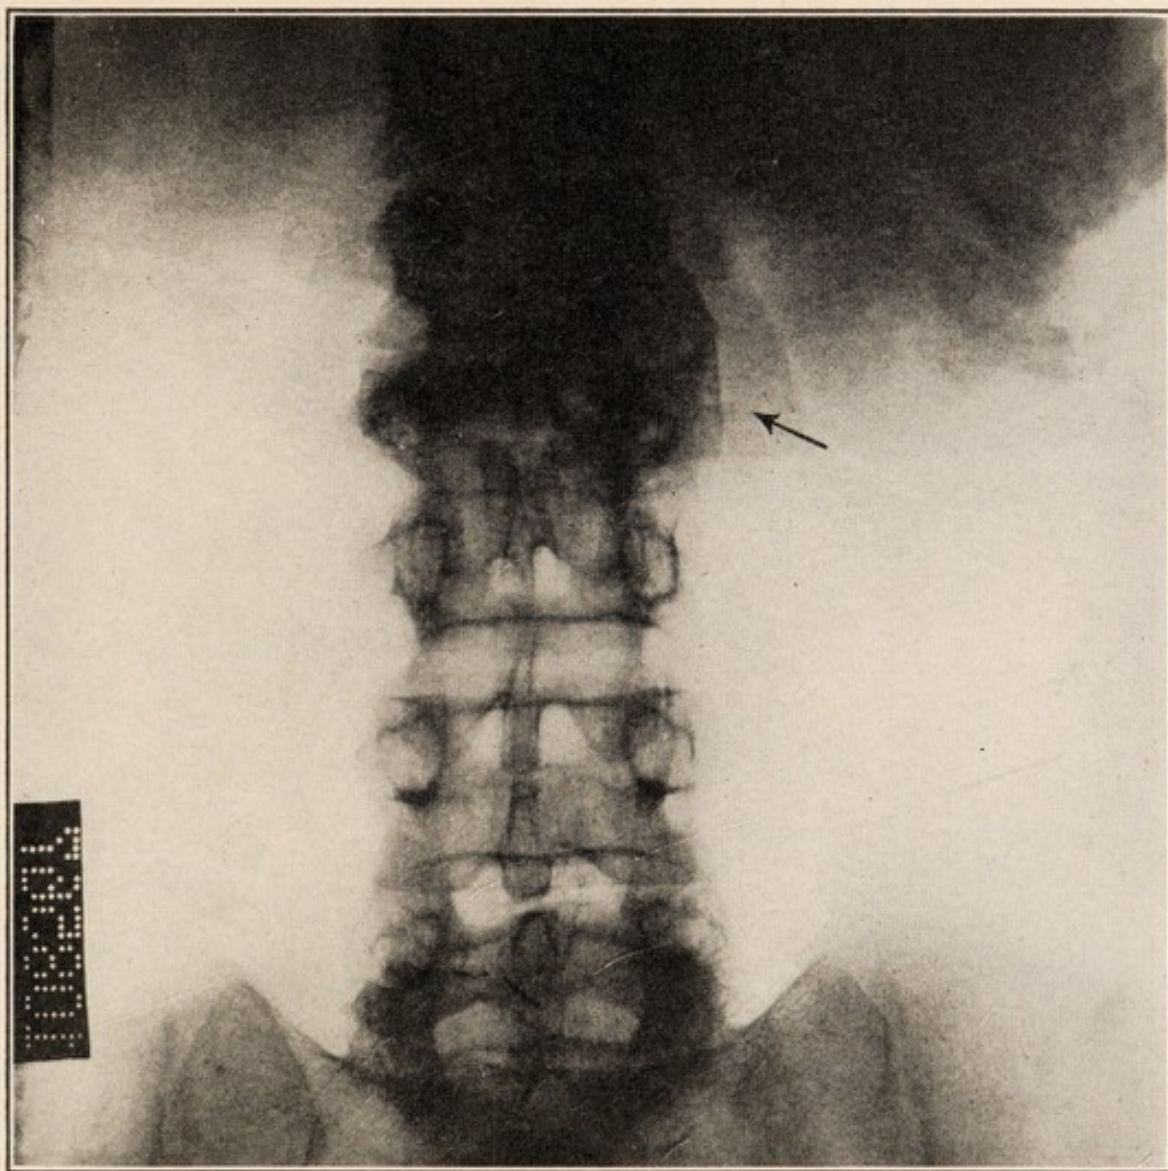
Compression fracture of the spine, antero-posterior view. (Courtesy of Doctor Charles A. Waters from the Johns Hopkins X-ray Laboratory.)
